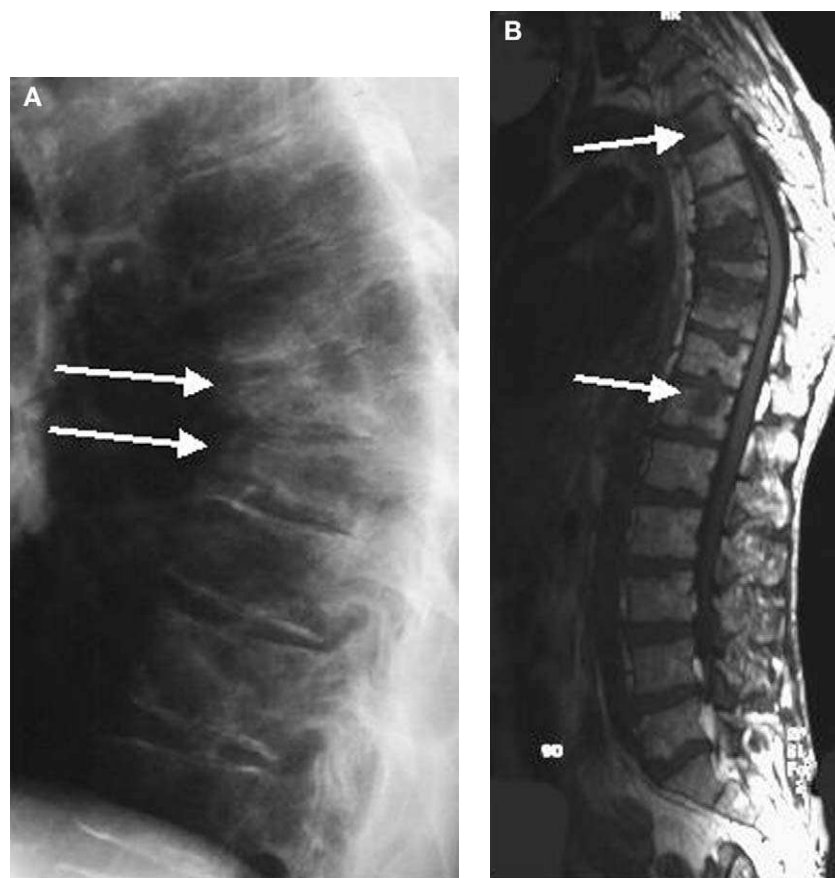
Pathologic vertebral fracture caused by bone metastasis. (A) Conventional spine radiograph depicts fractures of two thoracic vertebrae (arrows). Sagittal T1-weighted (B) and short T1 inversion recovery MR images (C) show multiple neoplastic lesions (arrows) of the spine in addition to the vertebral fractures.
